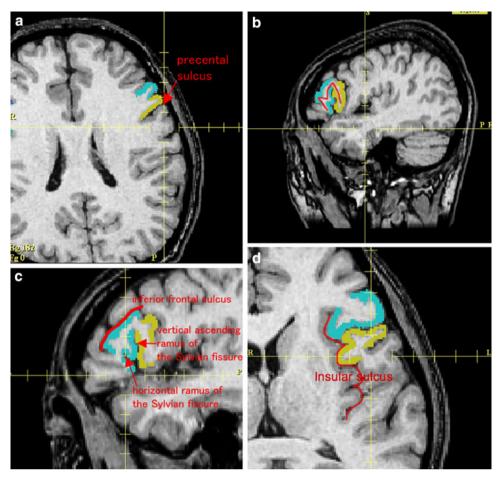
The anatomical definition of pars opercularis (approximate BA 44) and triangularis (approximate BA 45). In MR images of a control subject with typical sulcal variation, pars opercularis and triangularis are marked in yellow and blue respectively. a An axial slice in which the pre-central sulcus is clearly identified. b A sagittal slice in which inferior frontal gyrus looks like a letter "M"-shaped structure locating just anterior to precentral sulcus. The posterior part of "M"-shape is pars opercularis (approximate BA 44), which is located aside with the precentral sulcus. The central and anterior part
